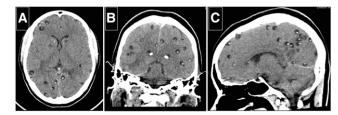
Computed tomography showing multiple vesicular lesions (case 2).
